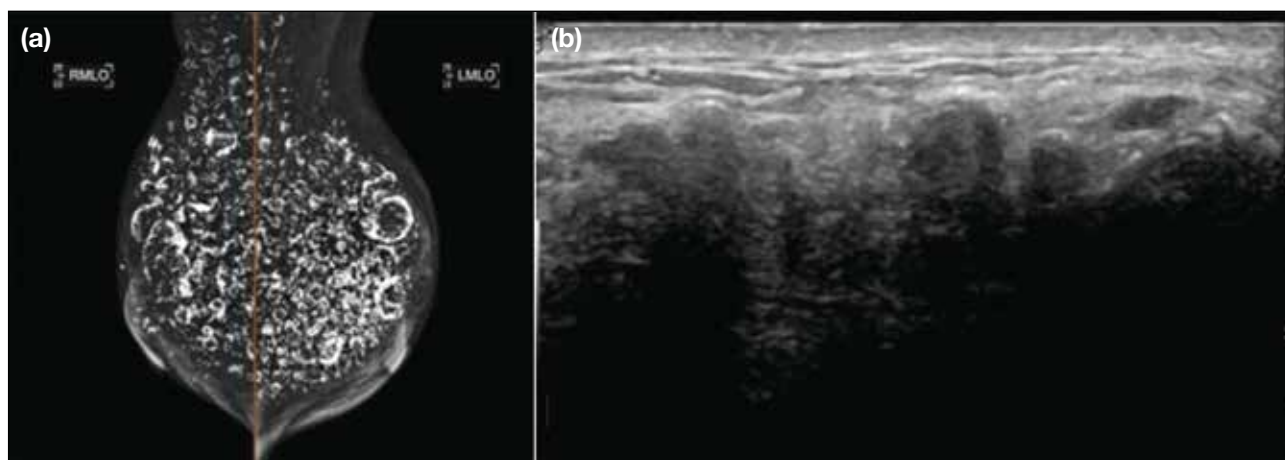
A patient with paraffin injection breast augmentation. (a) Mammography showing multiple coarse calcifications, some ring-shaped, representing previous paraffin injection with calcified granuloma. (b) Ultrasonography of the breast showing these calcified granulomata casting posterior acoustic shadow and limiting the assessment of deep breast tissue.
